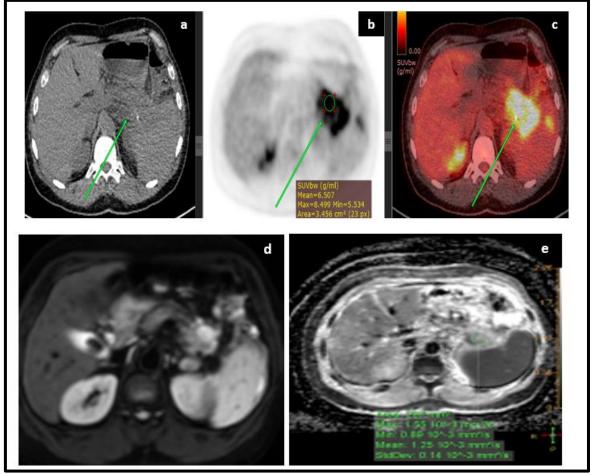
[a] Axial CT image showing pancreatic tail lesion. [b] Axial MIP FDG-PET image showing hypermetabolic pancreatic tail lesion with SUVmax 8.4. [c] Axial fused PET-CT image at the same level showing the hypermetabolic pancreatic tail lesion. [d] Axial DWI showing increased signal of pancreatic tail lesion. [e] Axial ADC image showing relative decreased signal of pancreatic tail lesion with ADC mean value of 1.2x10⁻³.
